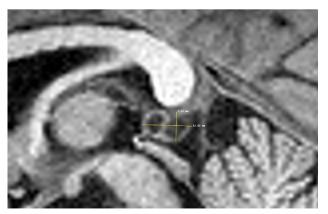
Enlarged sagital T-1 weighted MR image of participant #1 pineal cyst. The lines show the anteroposterior (12.62 mm) and craniocaudal (7.34 mm) measurements. All measurements included the cyst walls.
